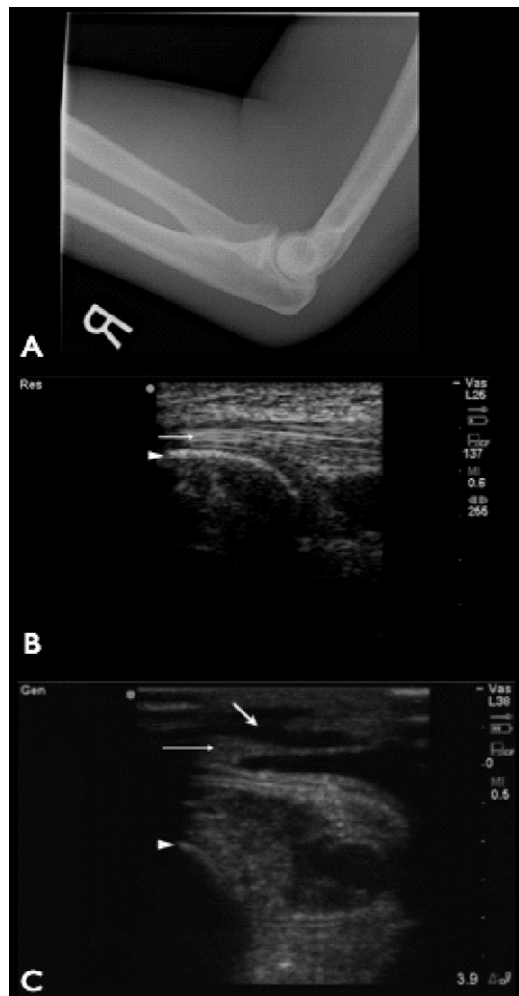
(A) Lateral elbow x-ray study demonstrating no fracture of joint effusion. (B) Ultrasound image in longitudinal orientation at distal humerus showing distal triceps tendon (thin arrow); olecranon cortex (arrowhead). (C) Ultrasound image in longitudinal orientation at distal humerus showing distal triceps tendon (thin arrow); anechoic area (thick arrow) demonstrating lack of tendon continuity; olecranon cortex (arrowhead).
